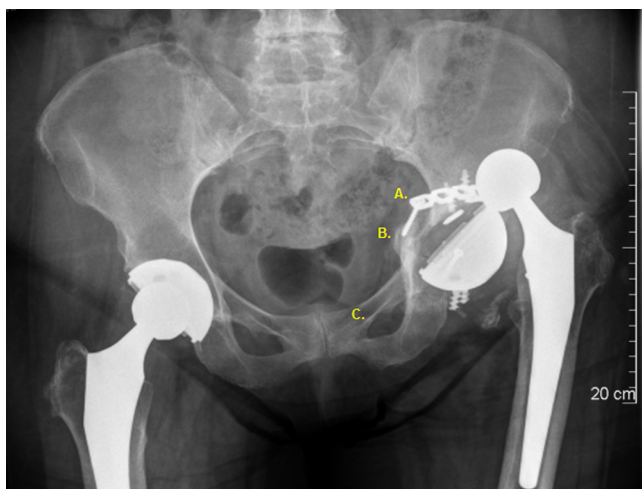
AP radiograph of the pelvis showing: A., visible fracture line; B., medial migration of the inferior pelvis; and C., obturator ring asymmetry. AP, anteroposterior.
